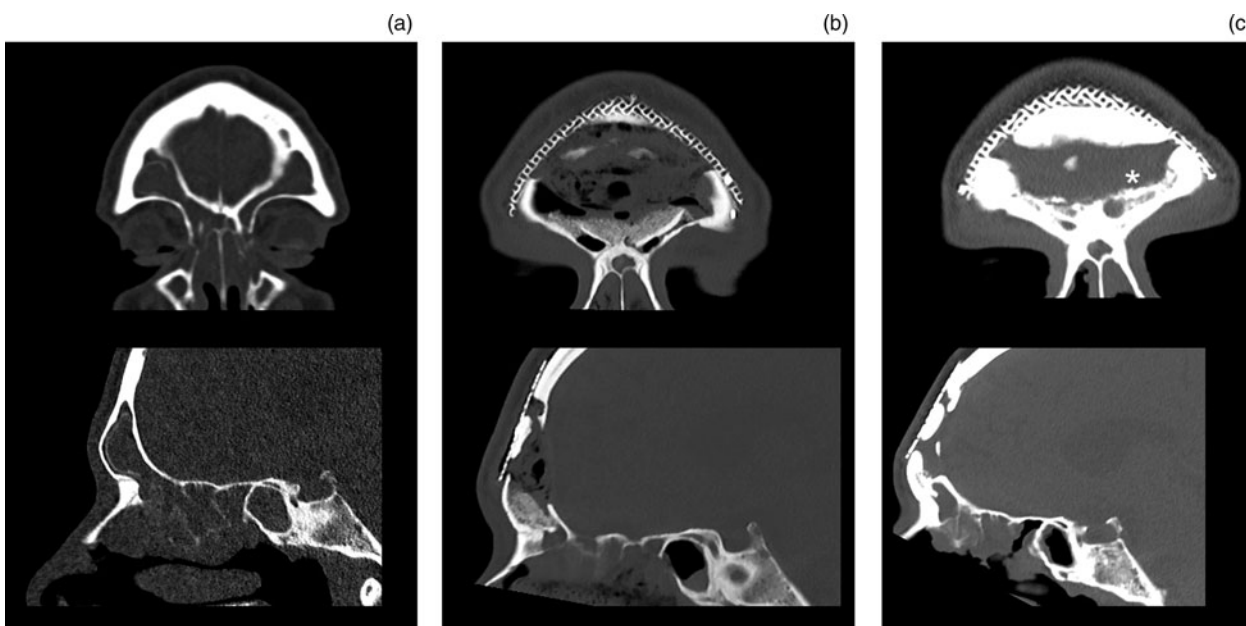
Patient 4 – non-contrast, coronal and sagittal computed tomography bone window images of the frontal sinus: (a) pre-operatively, (b) day 1 post-operatively and (c) 40 months post-operatively, demonstrating osseous integration and persistence of bone union at the frontal sinuses bilaterally (asterisk).
